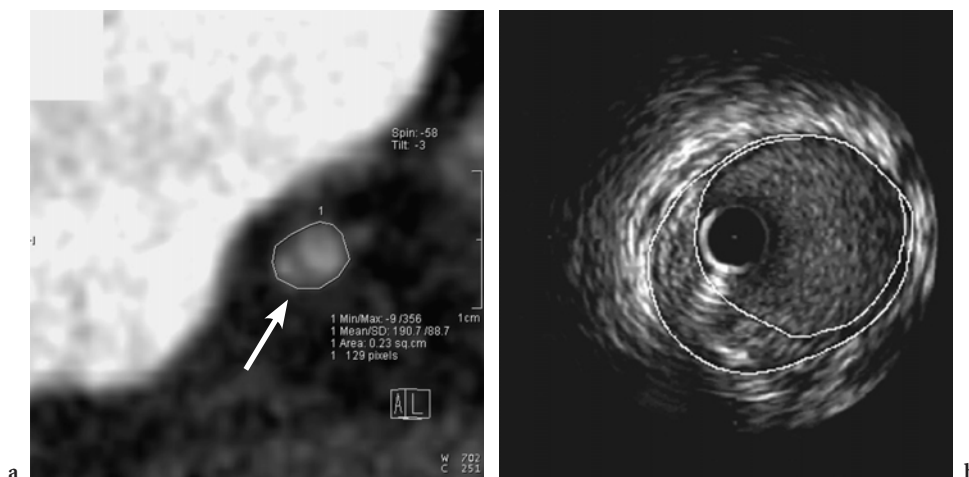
Quantification of atherosclerotic plaque dimensions with 16-slice CT. a Cross-section of the proximal LAD, with an eccentric atherosclerotic plaque (arrow), reveals a vessel area of 0.23 cm^2 . b The corresponding IVUS cross-section determines a vessel area of 0.21 cm^2
